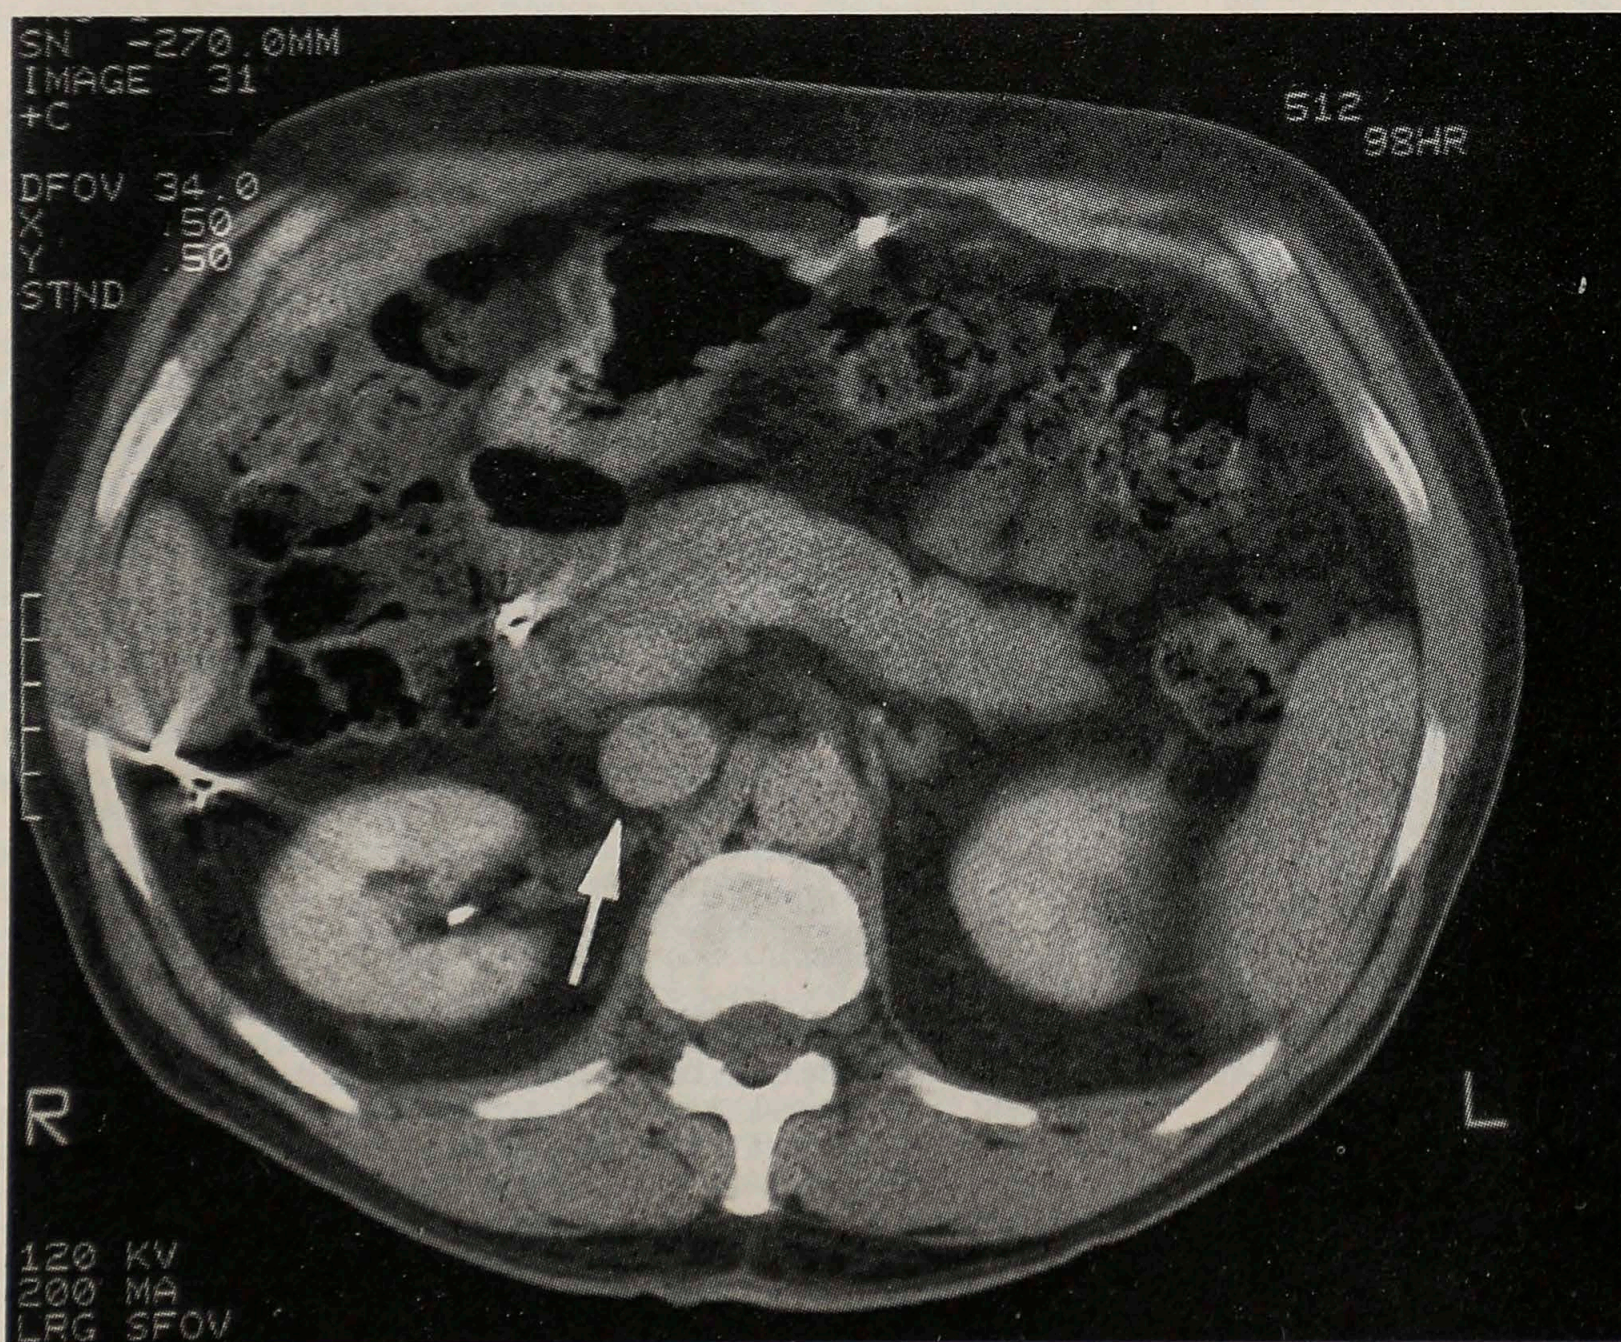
Computed tomography scan 2 years after repair. IVC is patent (arrow). There is no evidence of calcification.
